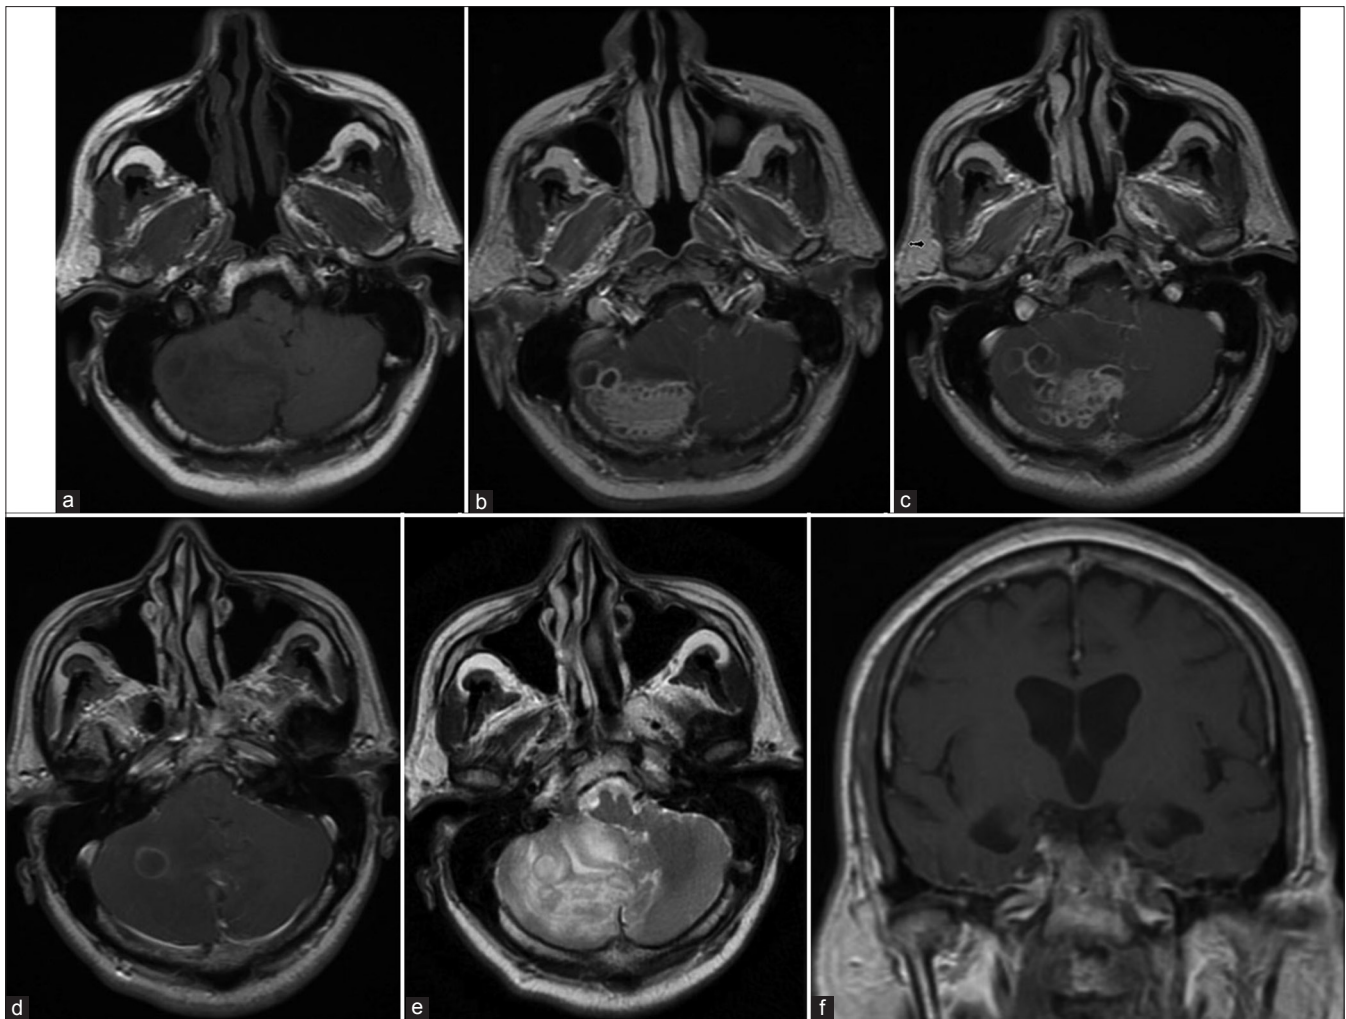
Noncontrast brain MRI (a) demonstrating an indistinct, heterogeneous lesion in the right cerebellar hemisphere causing mass effect and compression of the 4th ventricle. A cystic component can be seen laterally. Contrast-enhanced T1-weighted MRI (b-d) demonstrating a strongly enhancing lesion in the right cerebellar hemisphere. Innumerable, peripherally enhancing cystic structures are seen mostly surrounding, but also within, the area of enhancement. T2-weighted MRI (e) demonstrating diffuse hyperintensity within and surrounding the lesion. Contrast-enhanced T1-weighted MRI (f) demonstrating evidence of obstructive hydrocephalus with marked dilation of the lateral and third ventricles
